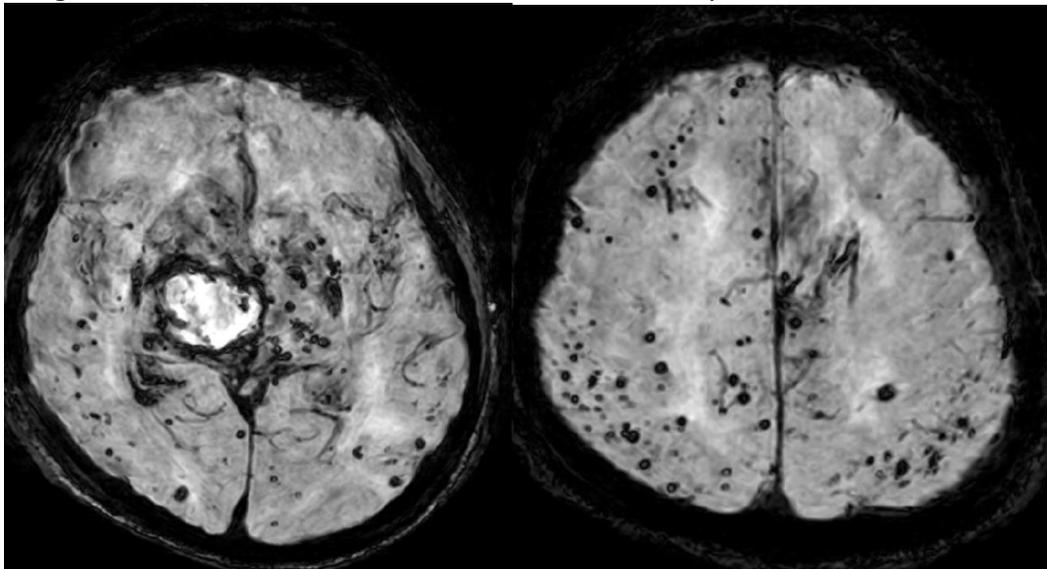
Image NO. 5+6: Brain MRI, 1 month after ICH: SWI sequence, axial scan
